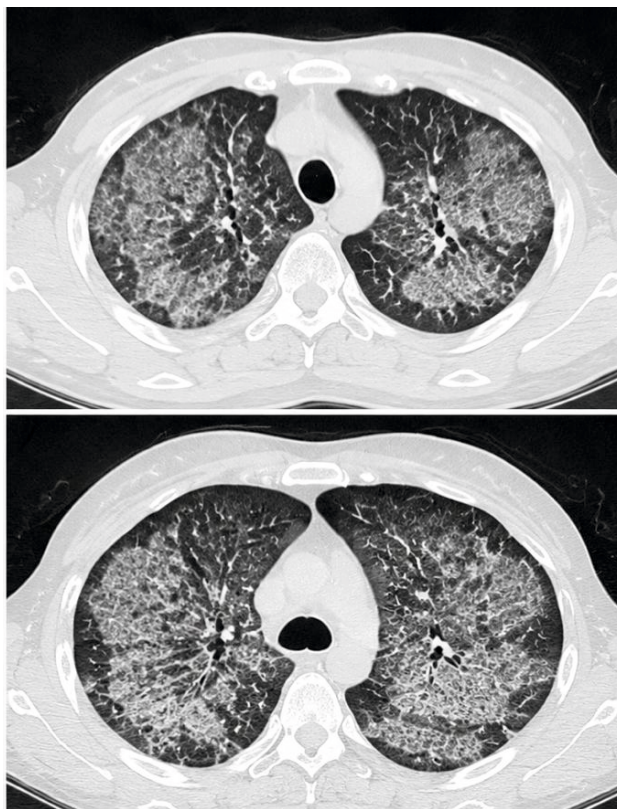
High-resolution CT chest showing diffuse bilateral ground-glass opacities with interlobular septal thickening (crazy-paving pattern), suggestive of diffuse alveolar hemorrhage.
